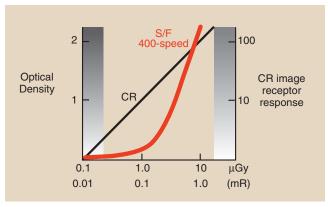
This region of the image receptor response curve suggests that significant patient radiation dose reduction may be possible with computed radiography (CR).
